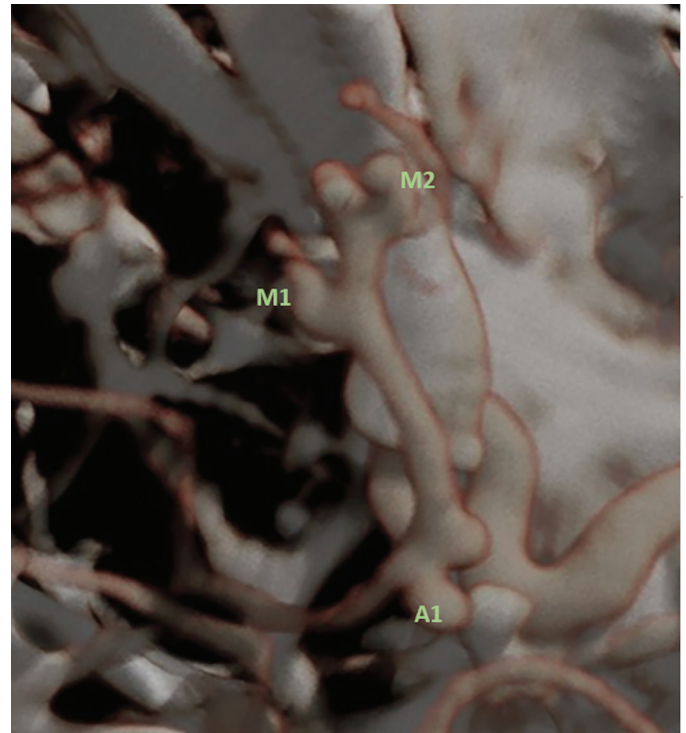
Three-dimensional reconstructed CTA magnified axial view showing the three aneurysms at the A1, M1 and M2 segments.
